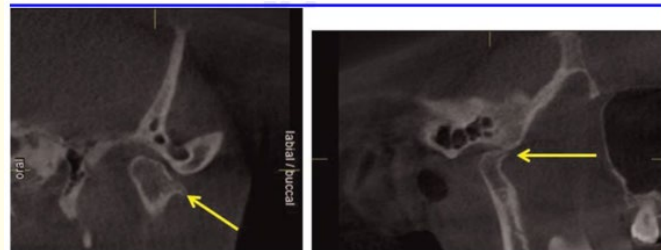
Osteophyte shown on CBCT [10].
